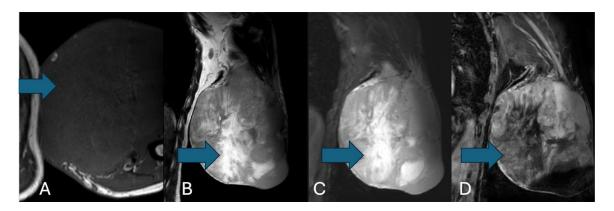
Magnetic resonance imaging of the left arm of the lesion shows a large lobulated heterogeneous soft tissue lesion with few nonenhancing areas of necrosis noted in the superficial plane of the medial aspect of the arm region on the left side. The lesion shows T1 hypointense (A), T2/STIR hetero-intense with few hyperintense areas within (B, C) with areas of blooming within the lesion. It shows post contrast enhancement (D). It measures approximately 115 \times 153 \times 127 mm. Diffuse subcutaneous edema with intervening streaks of fluid is noted in the thigh region. The underlying muscles appear normal. The head, greater and lesser tubercle and shaft of the left humerus show normal contour, morphology and marrow signal. No fracture or focal lesion.
